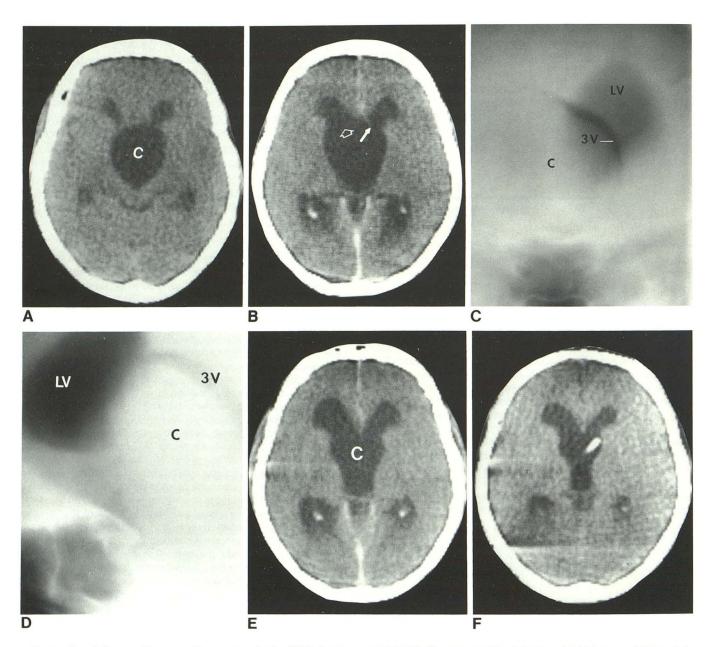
Case 2: 21-year-old woman with noncommunicating SSAC. A and B, CT scans. Large SSAC (C) has invaginated into third ventricle. Mild hydrocephalus due to obstruction of intraventricular foramina. Right foramen of Monro (B, open arrow) is widened secondary to invagination of cyst into right lateral ventricle. Septum pellucidum (solid arrow) is displaced to left. Anteroposterior (C) and lateral (D) radiographs from pneumoencephalogram reveal large SSAC causing severe compression and upward displacement of third
